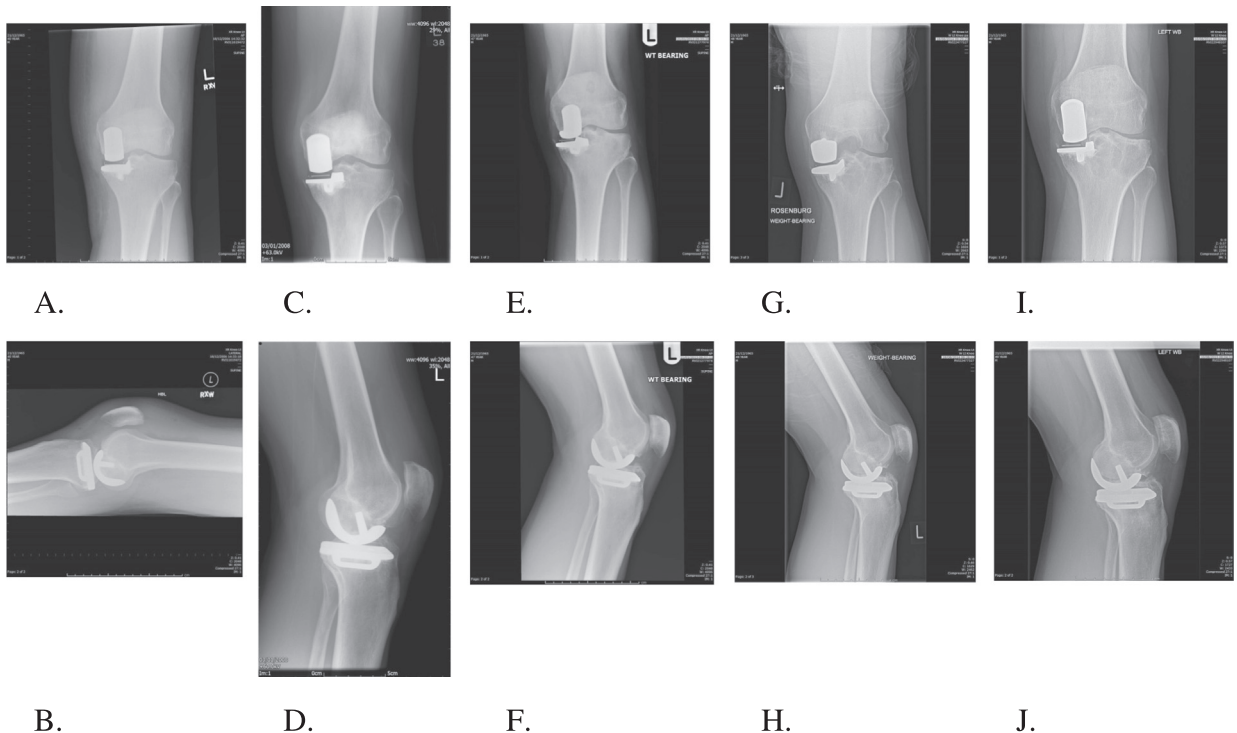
Pre-operative serial radiographs showing progression of the tibial geode over several years.
